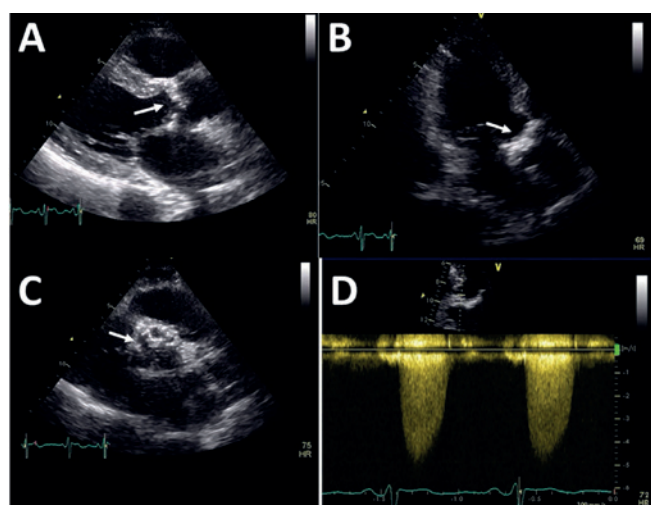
Transthoracic echocardiographic images of a patient with granulomatosis with polyangiitis. (A) parasternal long-axis, (B) apical 3-chamber and (C) parasternal short-axis views showing calcified aortic valve (arrows). (D) is CW-Doppler showing a peak aortic jet velocity of 4.5 m/s, consistent with severe aortic stenosis. [Reproduced from Ali et al (43). Licensed under CC BY 4.0)]
